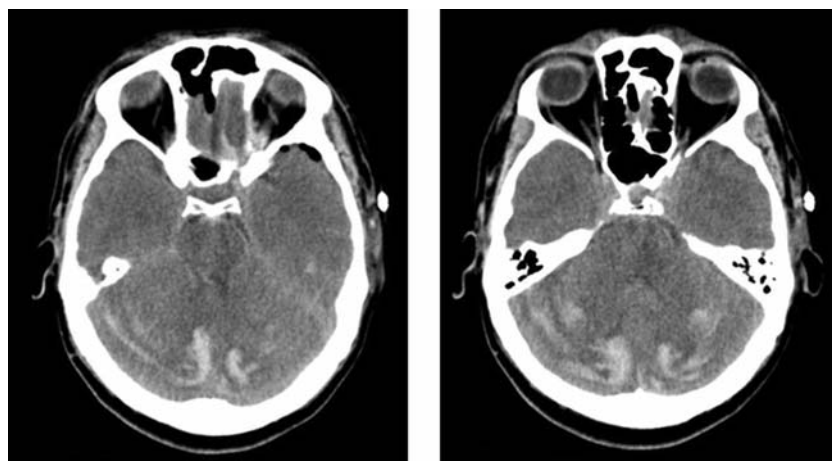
Immediate postoperative and post seizures CT head without contrast showing bilateral hemorrhagic foci in the posterior fossa remote from the surgical site.
